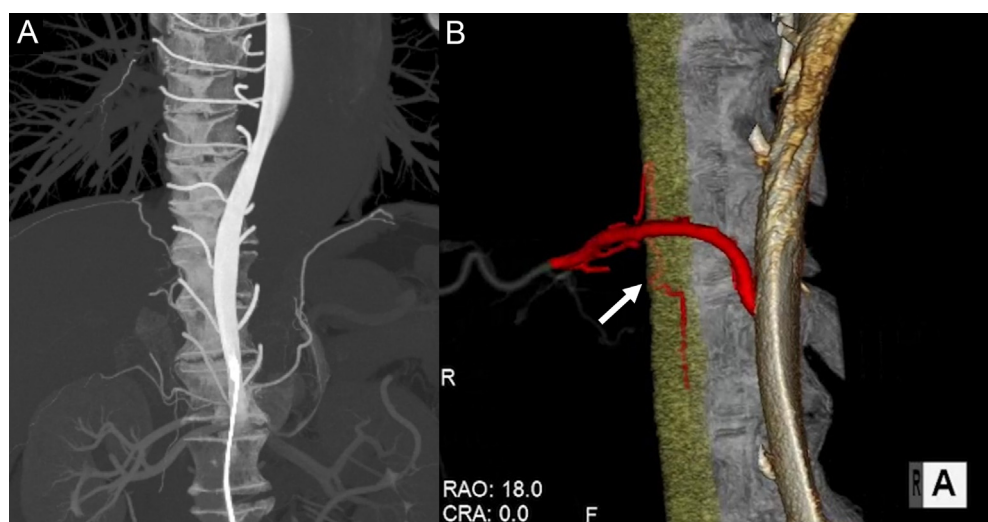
A maximum intensity projection of the intraarterial CT angiography image (A) shows adequate contrast effect in the TL and intercostal arteries. The volume rendering image (B) shows an anterior spinal artery branch from the right 10th intercostal artery via the posterior spinal artery forming a characteristic hairpin curve (white arrow).
